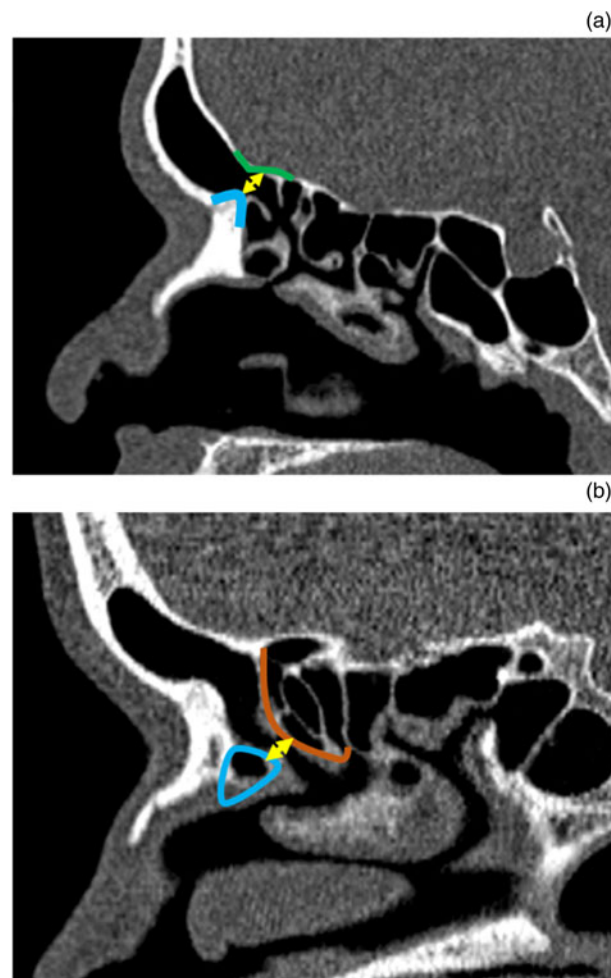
(a) Non-contrast parasagittal computed tomography (CT) images of the paranasal sinus, showing the frontal sinus ostium (yellow double-headed arrow) located at the level of frontal beak (blue solid line), measured from frontal beak anteriorly to the skull base posteriorly (green solid line). (b) Non-contrast parasagittal CT images of the paranasal sinus, showing the frontal recess (yellow double-headed arrow), measured from posterior wall of the agger nasi cell anteriorly (blue solid line) to the ethmoidal bulla posteriorly (orange solid line).
